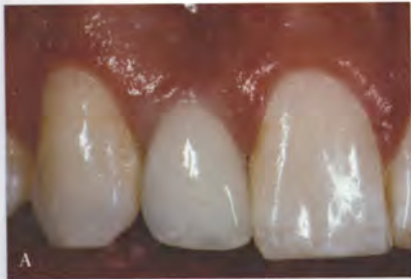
The final restoration (A) and radiograph (B) of the single-tooth implant replacing the congenitally missing lateral incisor at 1-year postinsertion.
